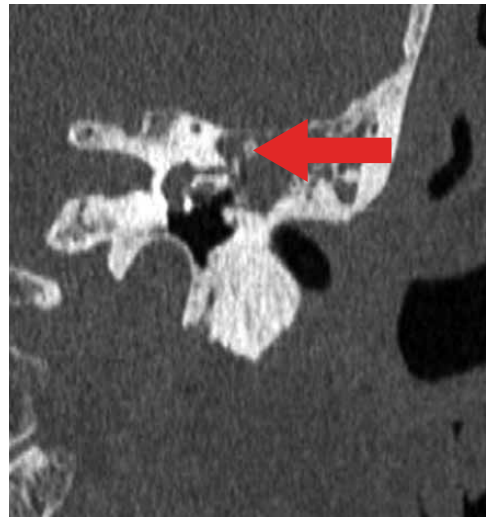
Head CT scan axial view showing opacification of the right mastoid air cells and erosion of the right lateral semicircular canal.
